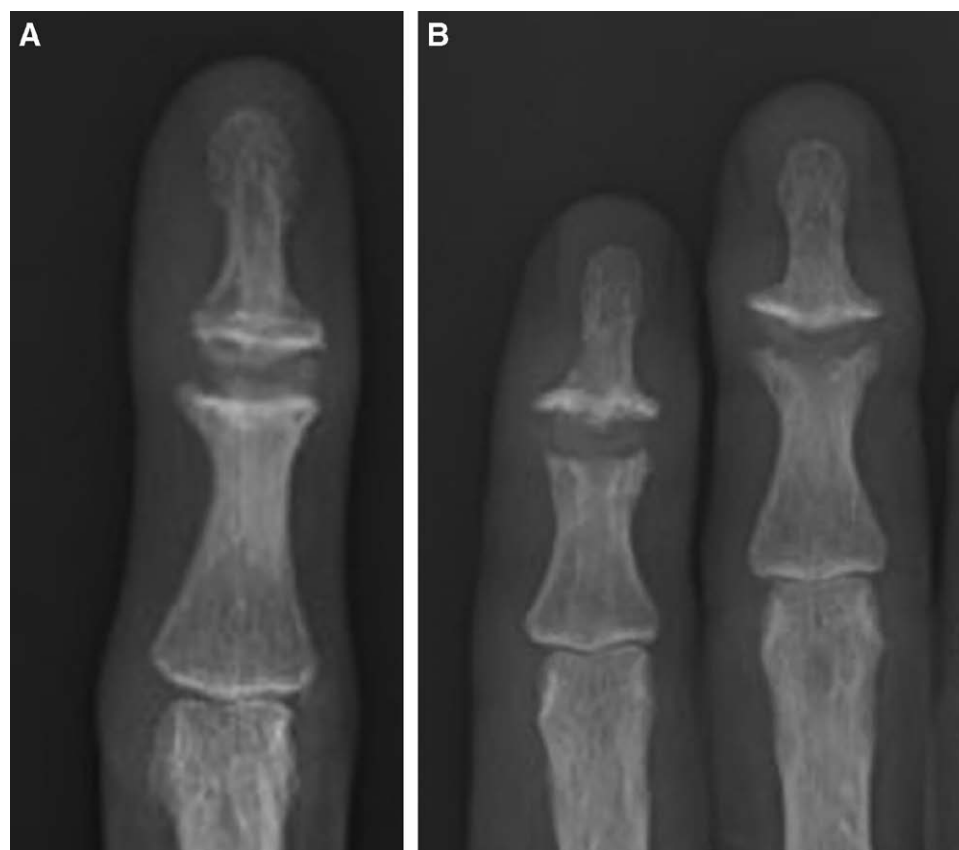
Postoperative results. A, Postoperative radiograph of the right middle finger of a 56-year-old woman using the conventional approach. B, A postoperative radiograph of the right index and middle fingers of a 63-year-old woman who was treated using the IMI method.
